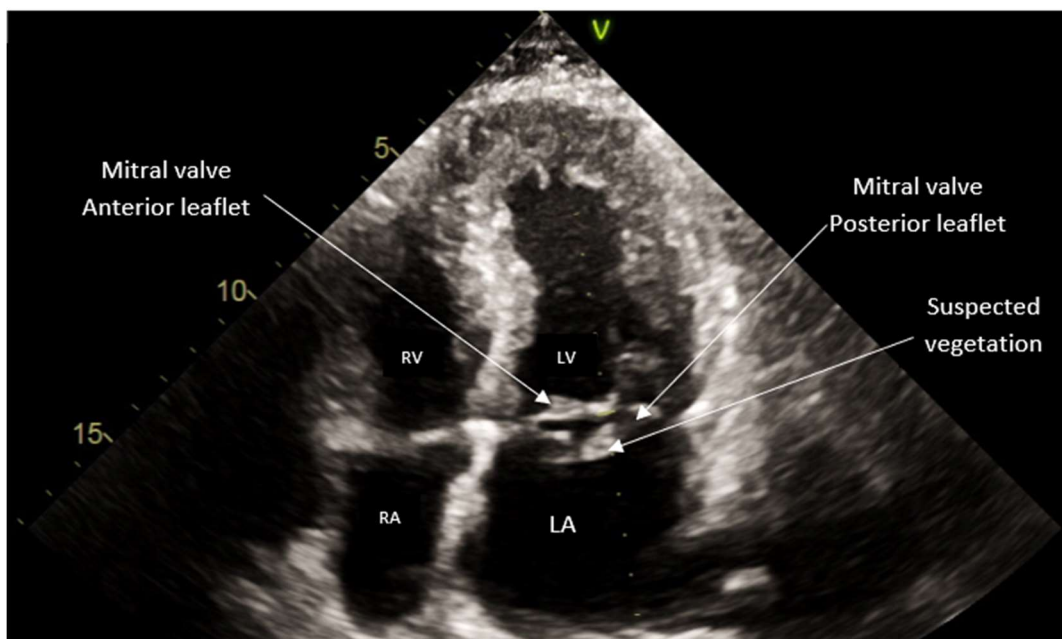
Transthoracic echocardiogram four-chamber view demonstrating mitral valve vegetation.
